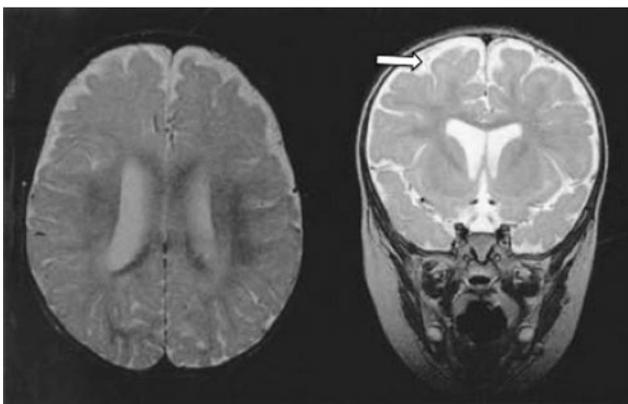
Enlarged subarachnoid spaces. Axial and coronal T2-weighted high-resolution magnetic resonance images of the brain demonstrating enlargement of the subarachnoid space. Note the visible arachnoid layer, with most of the vessels (*arrow*) beneath it and only the dura above it.
